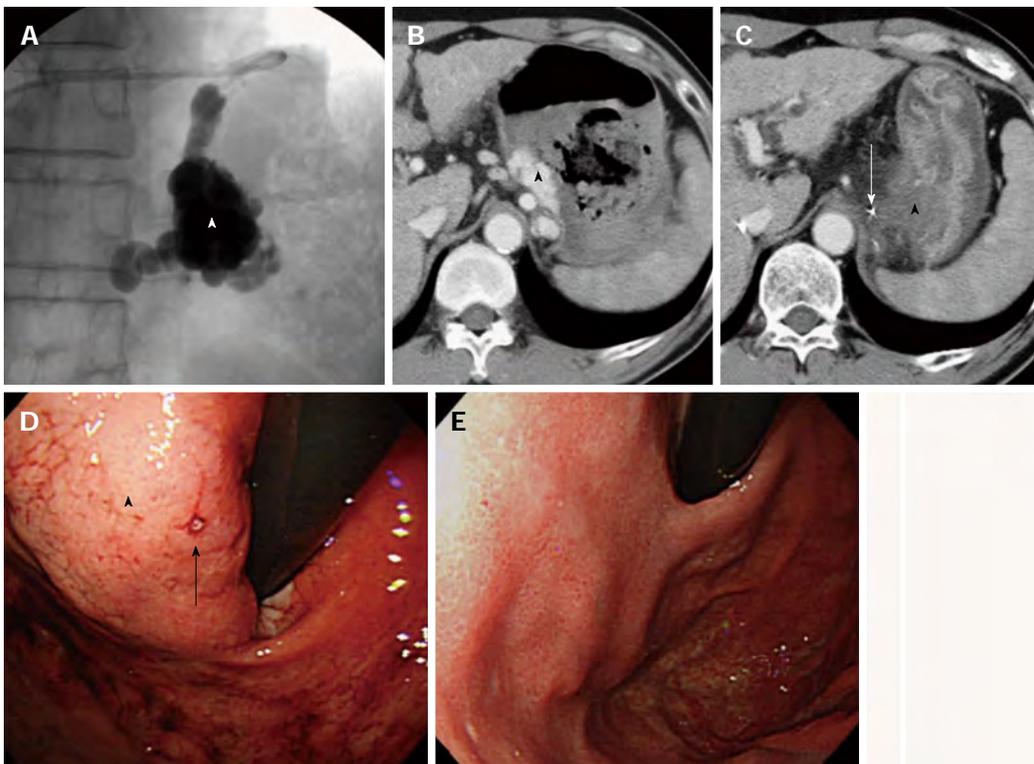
Gastric varices with a gastrocaval shunt (case 8). A: A balloon catheter was inserted into a gastrocaval shunt and 18 mL of 5% EOI was injected through the microcatheter that had been advanced close to the gastric varices; B: Contrast-enhanced computed tomography (CE-CT) image taken before balloon-occluded retrograde transvenous obliteration (BRTO) shows gastric varices (arrowhead) with a massive hematoma; C: CE-CT image taken the day after BRTO shows complete thrombosis of the varices (arrowhead) and that the tip of the microcatheter (arrow) is close to the varices; D: Endoscopy performed before BRTO shows bleeding site (arrow) of the gastric varices (arrowhead); E: Endoscopy performed 3 mo after BRTO shows complete disappearance of the varices.
